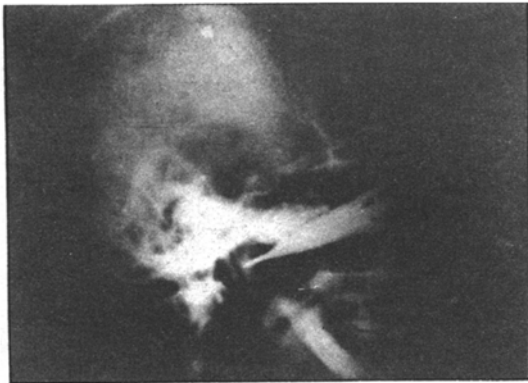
X-ray skull, lateral view showing the radio-opaque foreign body
